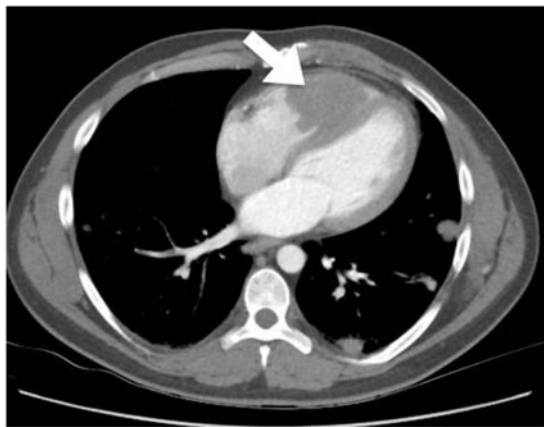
Chest computed tomography at presentation demonstrating a large right ventricular mass (white arrow). Additionally, several pulmonary metastases of the lung are displayed.
